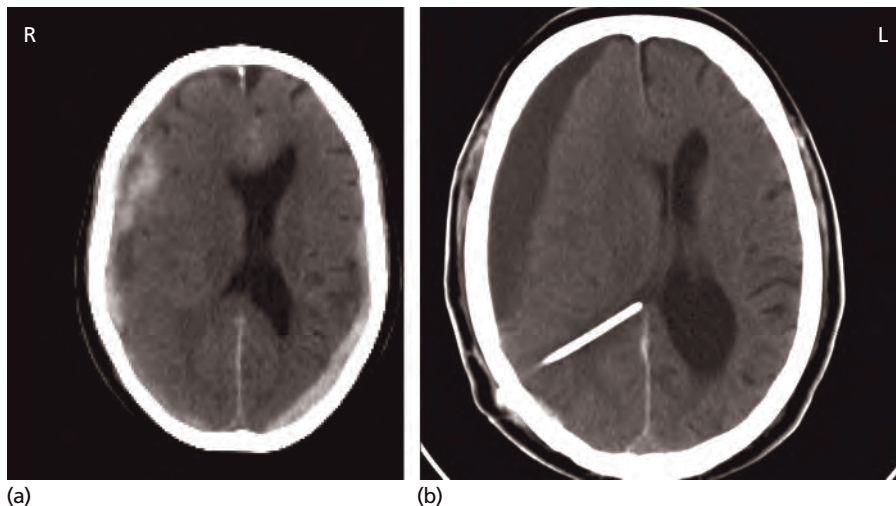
CT scan showing: (a) extensive fresh bilateral acute subdural haematoma with midline shift; and (b) large chronic subdural haematoma following insertion of intraventricular shunt.
